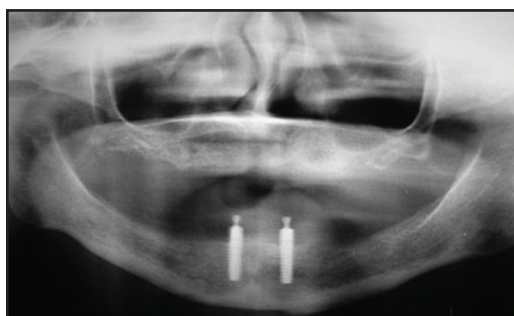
Panoramic radiograph taken when the implant supported mandibular overdenture was activated with o-rings (implant loading).
